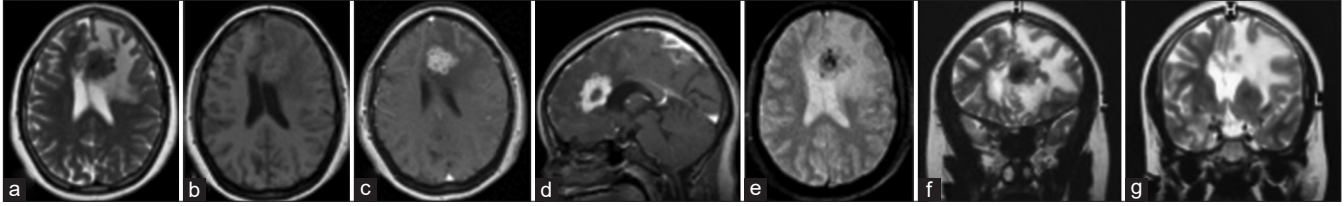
(a-g) The preoperation magnetic resonance imaging sequences demonstrate multiple intra-axial supratentorial lesions on the left of the frontal precentral location, and at least ten small lesions cluster together. These lesions are of low signal on T1-weighted imaging, the complex signal on T2-weighted imaging with areas of low/iso signal, surrounding vasogenic edema, and appear as a signal void in GRE. On postcontrast sequences, there is a peripheral cluster of ring enhancement of the small lesions (granulomas). (f and g) A mass effect is noted on the midline structures with subfalcine herniation.
